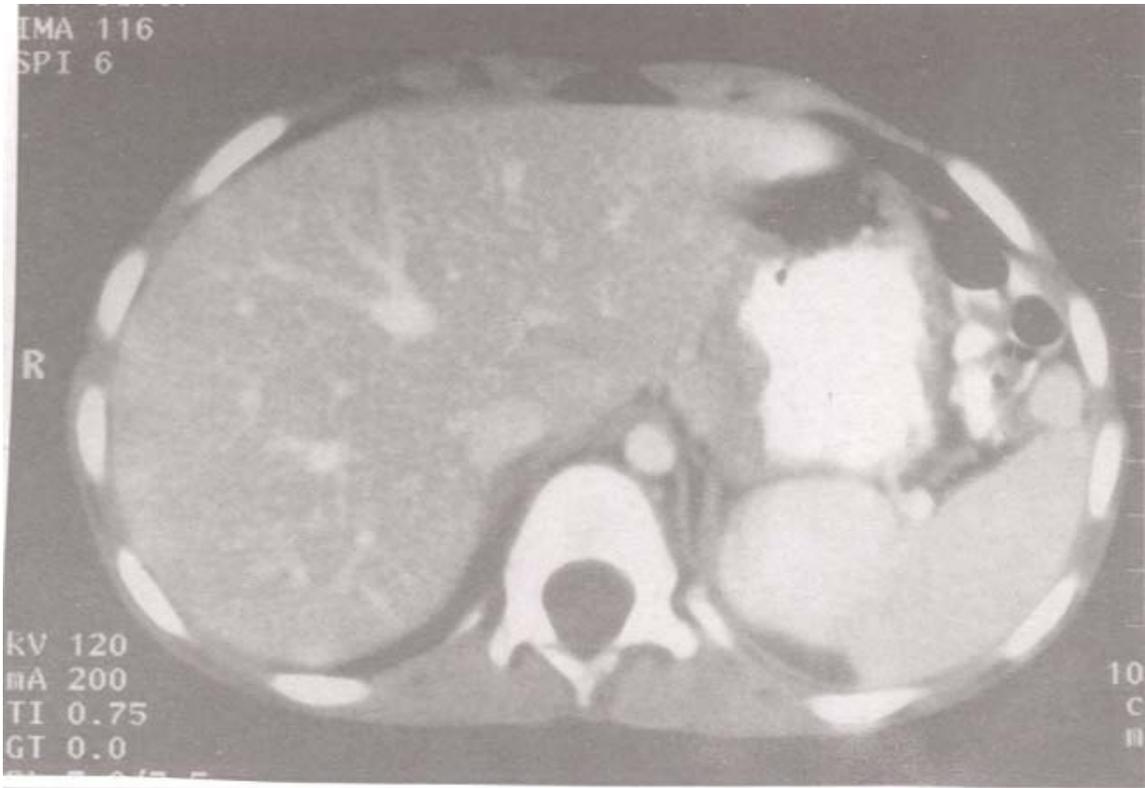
Computed tomography scan showing soft tissue lesion, medial to spleen, superior to left kidney with a local mass effect on spleen.
